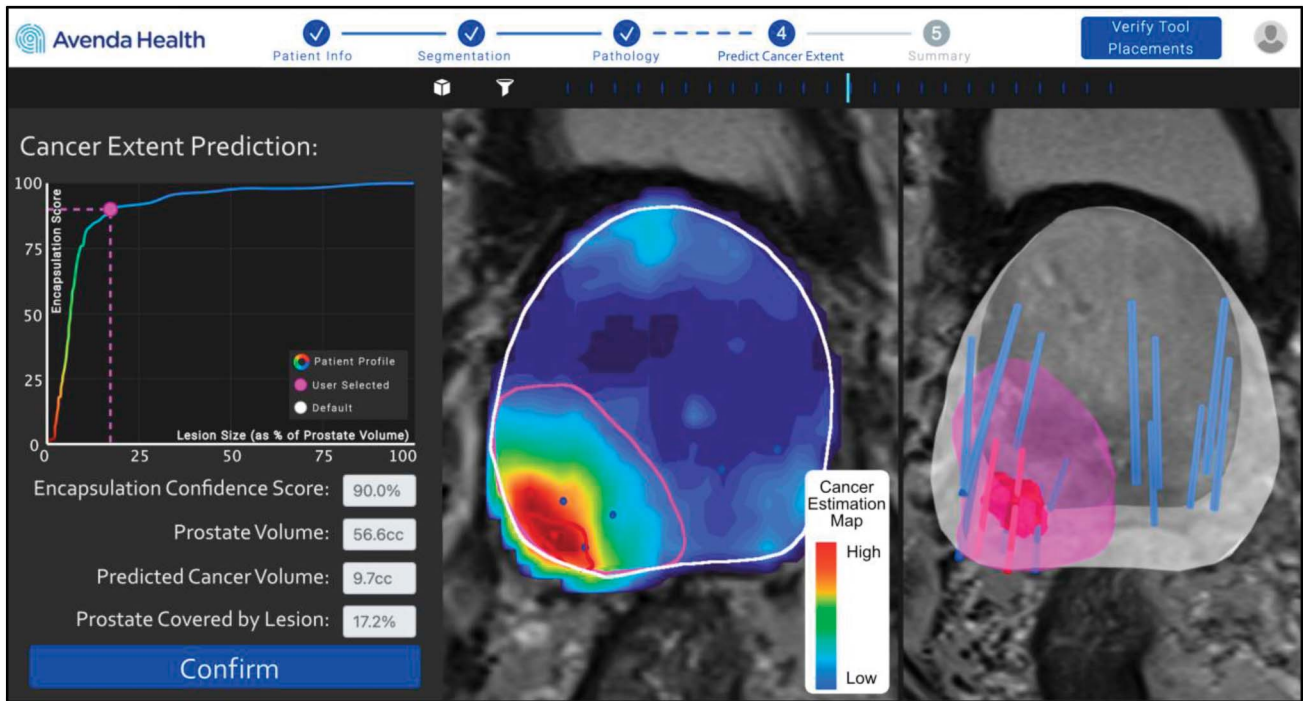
Exemplary image showing the prediction of cancer extent using artificial intelligence software. The central panel shows T2-weighted MRI overlaid with the cancer estimation map, biopsy cores bearing clinically significant prostate cancer (red circles), biopsy cores bearing benign tissue (blue circles), Prostate Imaging Reporting and Data System region of interest (red contour), the prostate capsule (white), and the currently selected cancer contour (pink). The right-hand panel shows the same elements in 3D. The left-hand panel shows the curve for encapsulation confidence vs cancer contour volume (as a percentage of the prostate), as well as other cancer contour statistics.
